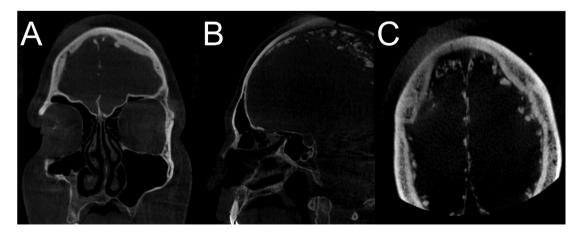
CBCT coronal (A), sagittal (B), axial (C) slices of a patient with NBCCS. Note the falx cerebri calcifications at all slices.
